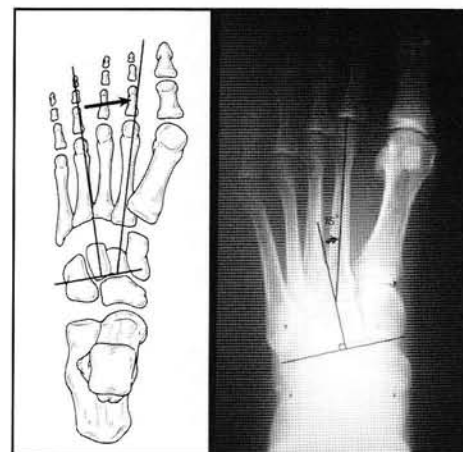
Metatarsus Adductus angle as described by Weissman on DP weightbearing Radiograph.
